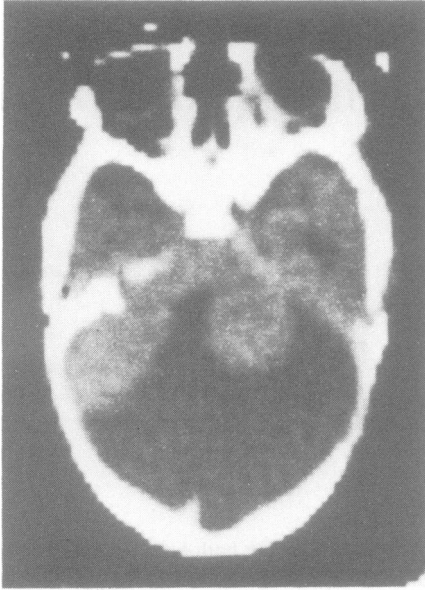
Case 1: CT showing a large cyst of CSF attenuation in the posterior fossa. Small remnant of brain tissue anteriorly on the floor of the posterior fossa. The cerebellar vermis is absent. The cerebellar hemispheres are hypoplastic.
